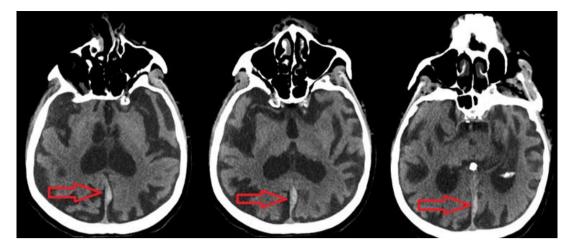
Acute interhemispheric fissure subdural hematoma (red arrows) in brain CT
